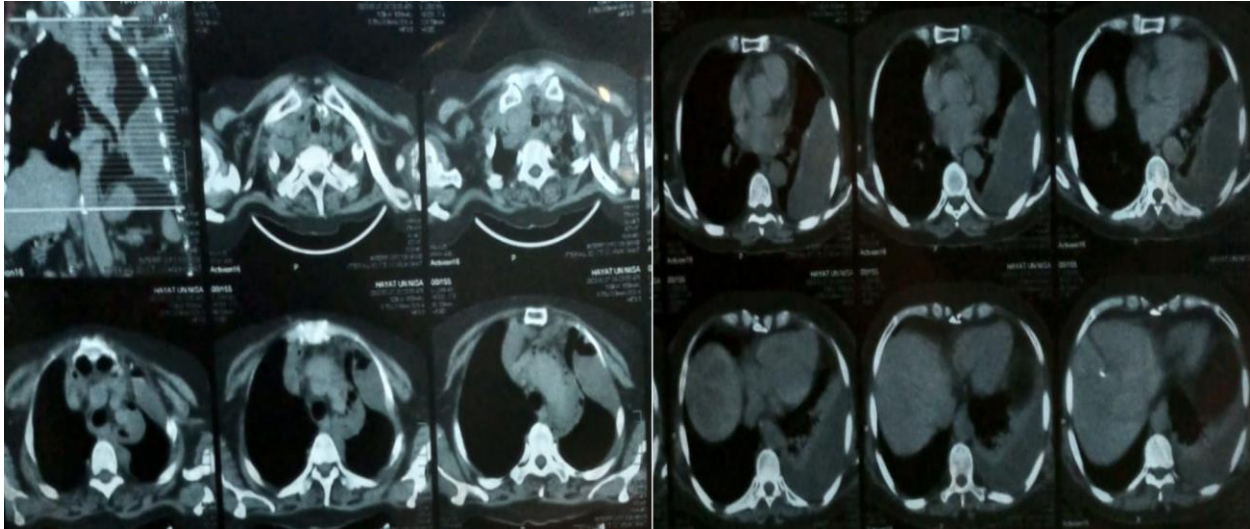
CT thorax images of the patient
